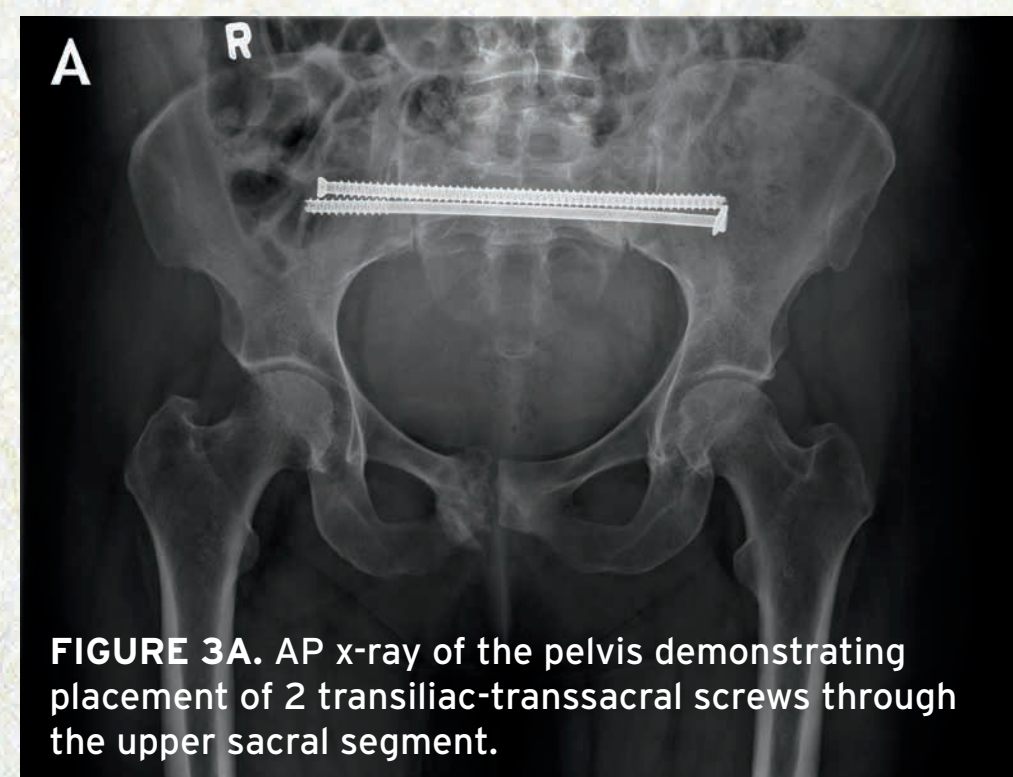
AP x-ray of the pelvis demonstrating placement of 2 transiliac-transsacral screws through the upper sacral segment.
